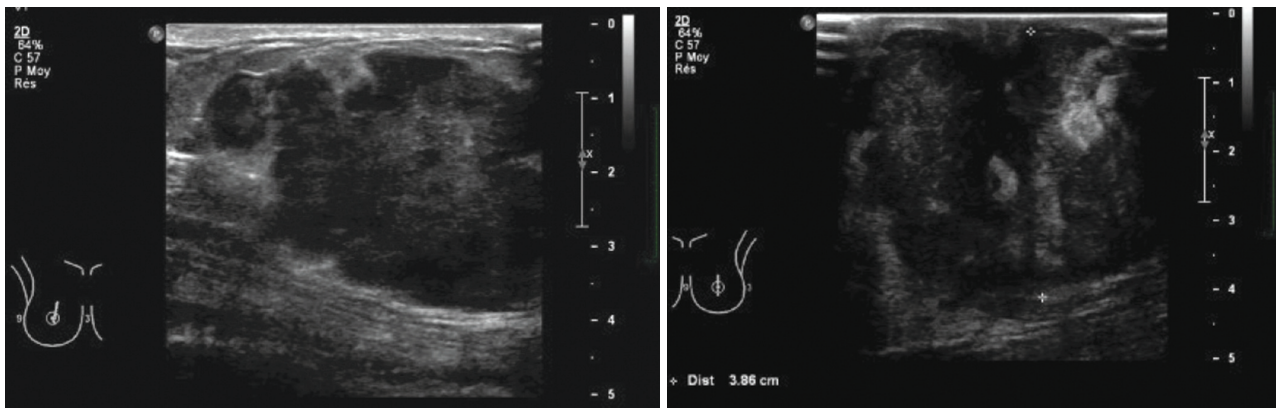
(a) Ultrasound right breast longitudinally. (b) Ultrasound the left breast. Ultrasound confirmed the presence of an irregular marginated lobulated hypoechoic and vascularized masses in both breasts.
